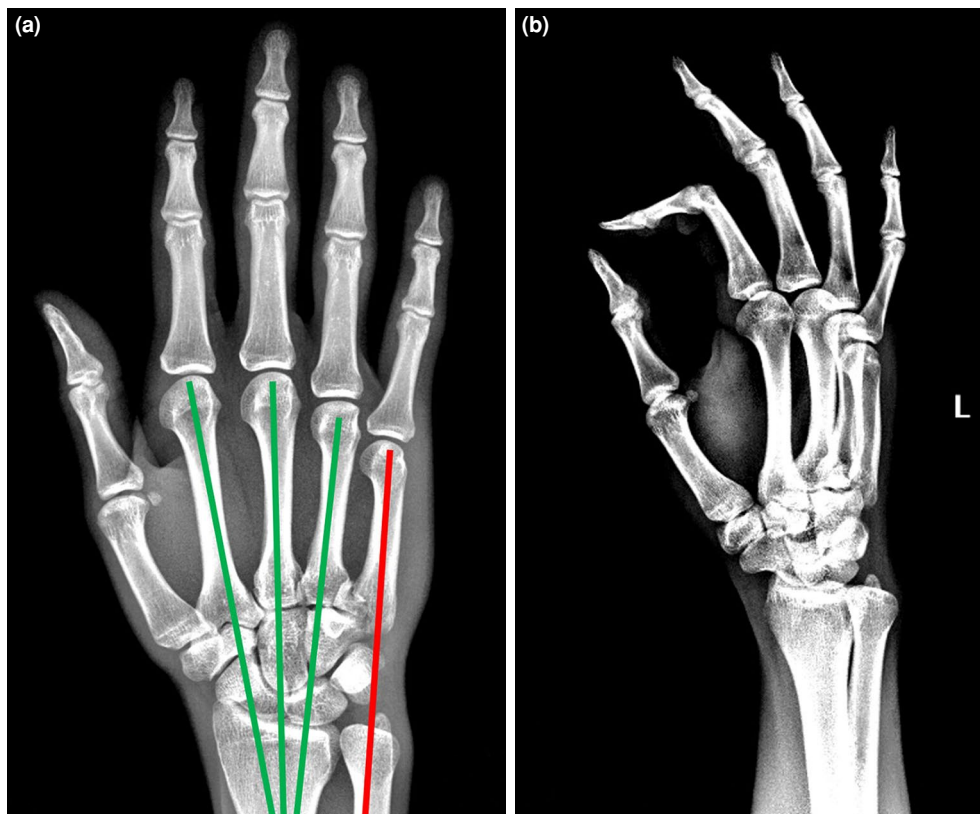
Pre- and postoperative X-ray images of a patient treated surgically. (a) AP X-ray with metacarpal cascade lines. Lines are drawn along the axis of the metacarpals; green indicates anatomic, and red indicates dislocation, as it does not intersect with the others. (b) Preoperative oblique X-ray.
